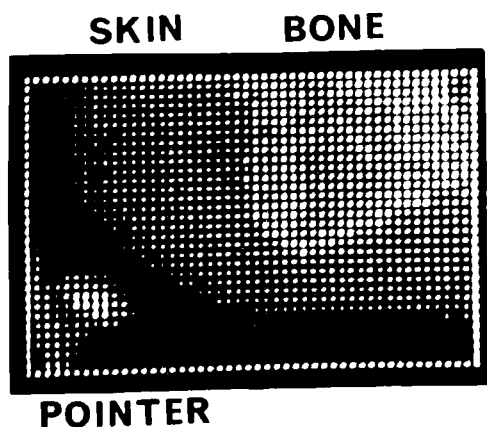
An example of the x-ray image of the anterior part of the mandible obtained by an overall scanning of a rectangular field.
